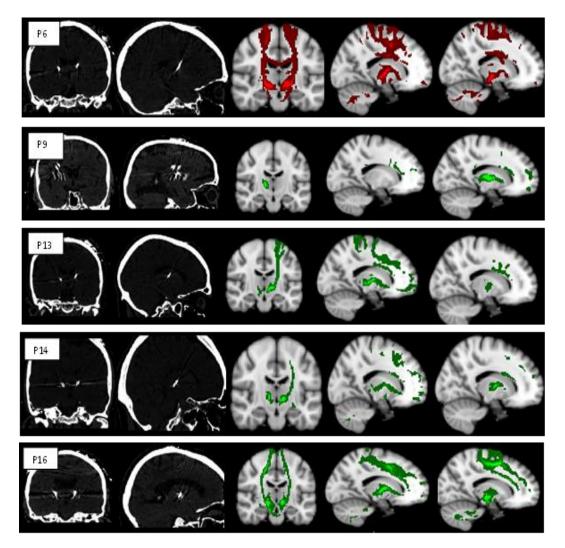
Connectivity profiles for air hunger at the average VAT coordinates for each patient in the 2-mm MNI standard brain. Electrode locations are presented for each patient. Improved patients when electrodes were activated (switched 'ON') (9, 13, 14 and 16) are showed in green, and unimproved patient when electrodes were activated (switched 'ON') (6) is shown in red. Coronal view (Y = 12), right sagittal view (X = 8), and left sagittal view (X = -8). Electrode location is shown on coronal and sagittal views of the postoperative CT scan (*left side*). The tractography was thresholded at probability levels 10/5000. (n=6).
